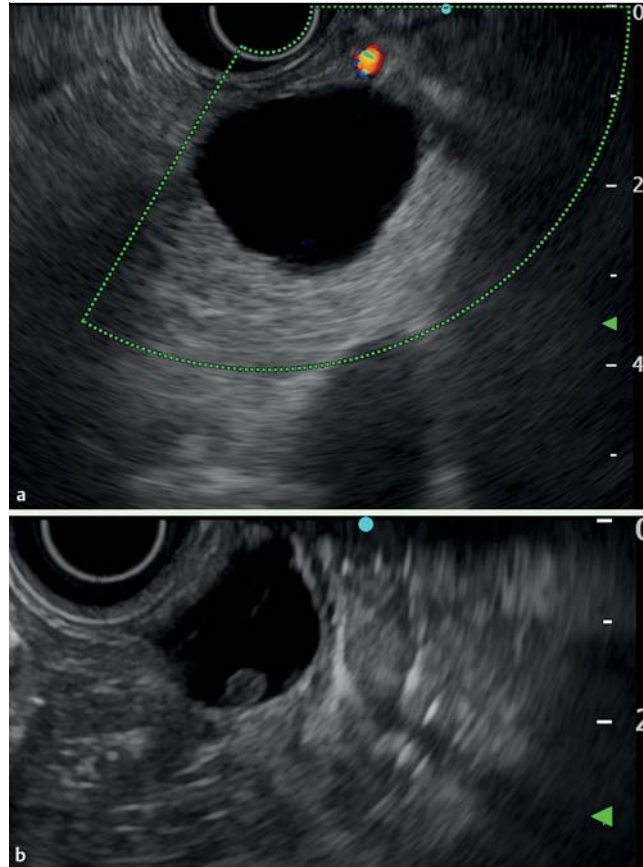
Endoscopic ultrasound of pancreatic cyst with an intracystic nodule.
